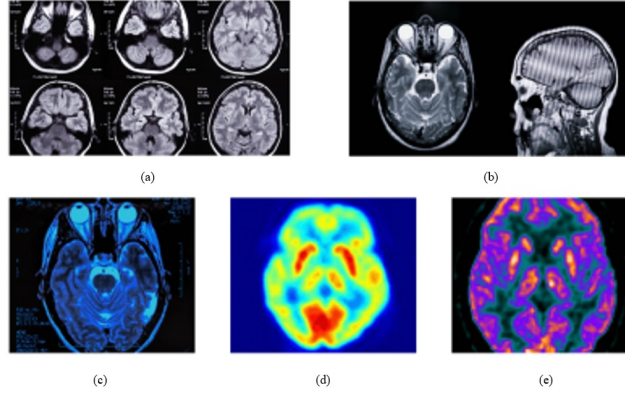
Examples of images from different modalities, (a) and (b) are MRI, and (c), (d), and (e) are nuclear imaging techniques [48].
